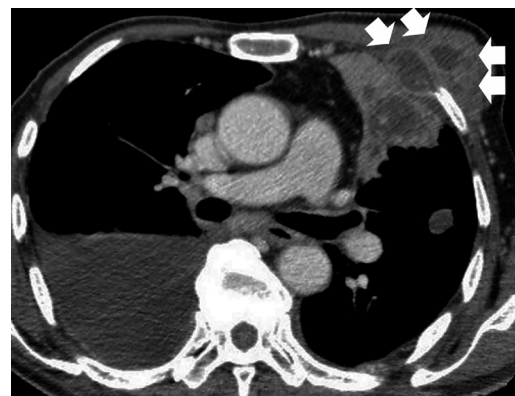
CT thorax axial image, with a large solid cystic mass along the anterior left pleura extending through the chest wall into the left pectoralis muscles and subcutaneous space (indicated by arrowheads). Note the aggressive, invasive appearance. This was subsequently proven on biopsy to be due to empyema necessitans from pulmonary mycobacterial tuberculosis. A bland right pleural effusion is also present.
